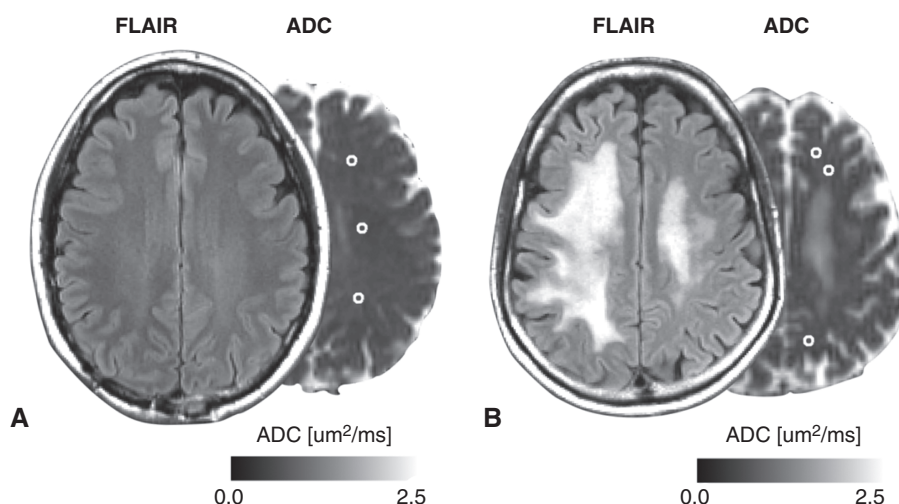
(A–B) Fluid-attenuated inversion recovery (FLAIR) images and ADC maps of two representative patients with GBM who were treated with ICIs. Volumes of interest in the normal-appearing white matter are outlined in white. These are the post-ICI MRI of the same subjects as shown in Figure 2. Three spherical volumes of interest, 5 mm in diameter, were put in the central semiovale in the anterior, middle, and posterior area around 3 mm above the upper end of the lateral ventricles contralateral to the tumor. (B) because this patient had white matter abnormality in the contralateral central semiovale, volumes-of-interest were put to avoid the abnormality.
